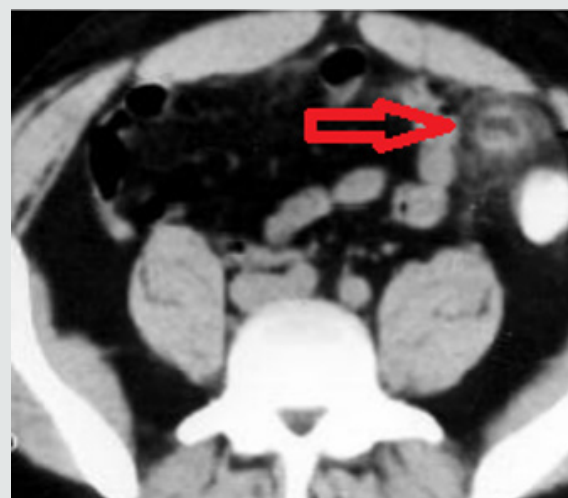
CT scan of the abdomen with an oval lesion (fat density) located in the left iliac fossa.
